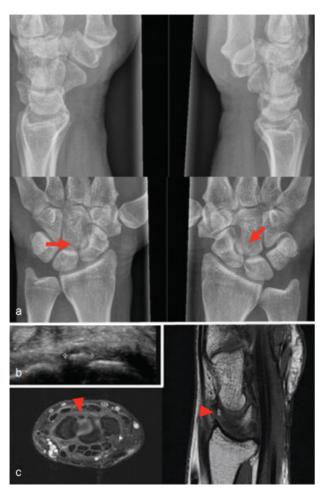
c (a) Lateral and anteroposterior (AP) radiographs of left and right wrists, showing a possible calcification (arrow). (b) Axial sonography showing the ossicle between the lunate and scaphoid. (c) Axial and sagittal MRI showing the os epilunatum on the dorsal side of the scapholunate ligament (arrowhead).
